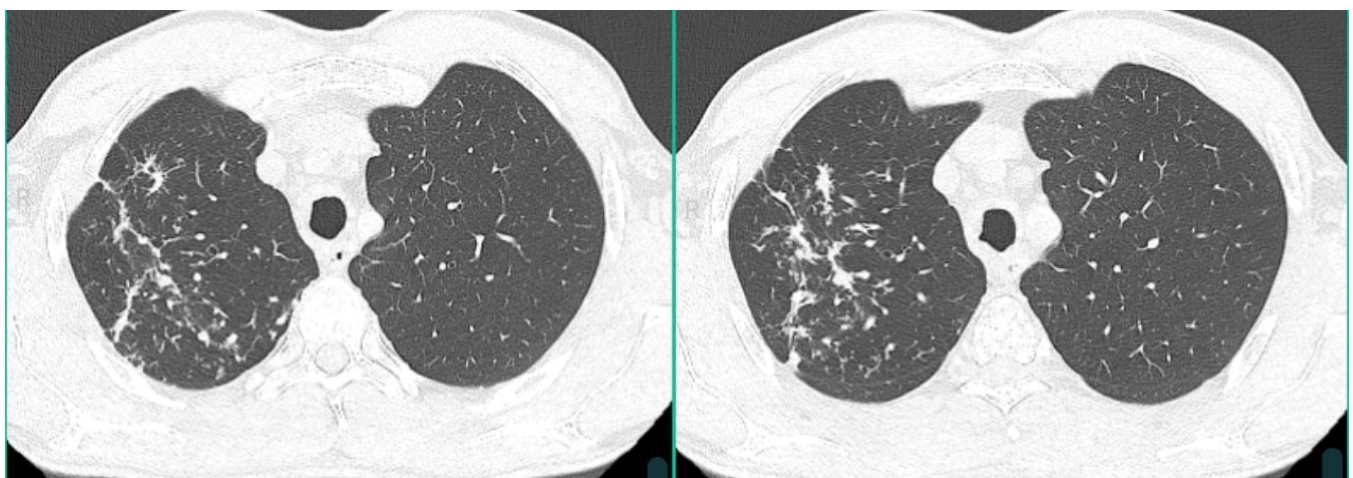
CT exam of the thorax highlights multiple micronodules and small juxacentimeter pulmonary nodules distributed predominantly in the right upper lobe described as “tree-in-bud” pattern.
